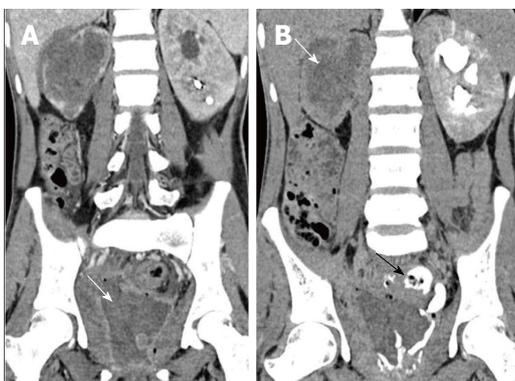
Eosinophilic cystitis. A 25 years old man who presented with hematuria and worsening irritative symptoms over past one year. Clinical suspicion was that of a bladder malignancy. A: Coronal reformatted CECT in nephrographic phase shows diffuse mass like bladder wall thickening and irregularity with air specks in the wall. Mass like soft tissue is replacing entire right kidney with perinephric spread; B: Delayed coronal CECT shows opacification of rectum through a fistulous communication (arrow). Note made of striated nephrogram in left kidney suggesting ongoing acute inflammatory process. Biopsy revealed eosinophilic infiltration and fibrosis within the bladder wall with no evidence of malignancy. CECT: Contrast-enhanced computed tomography.
